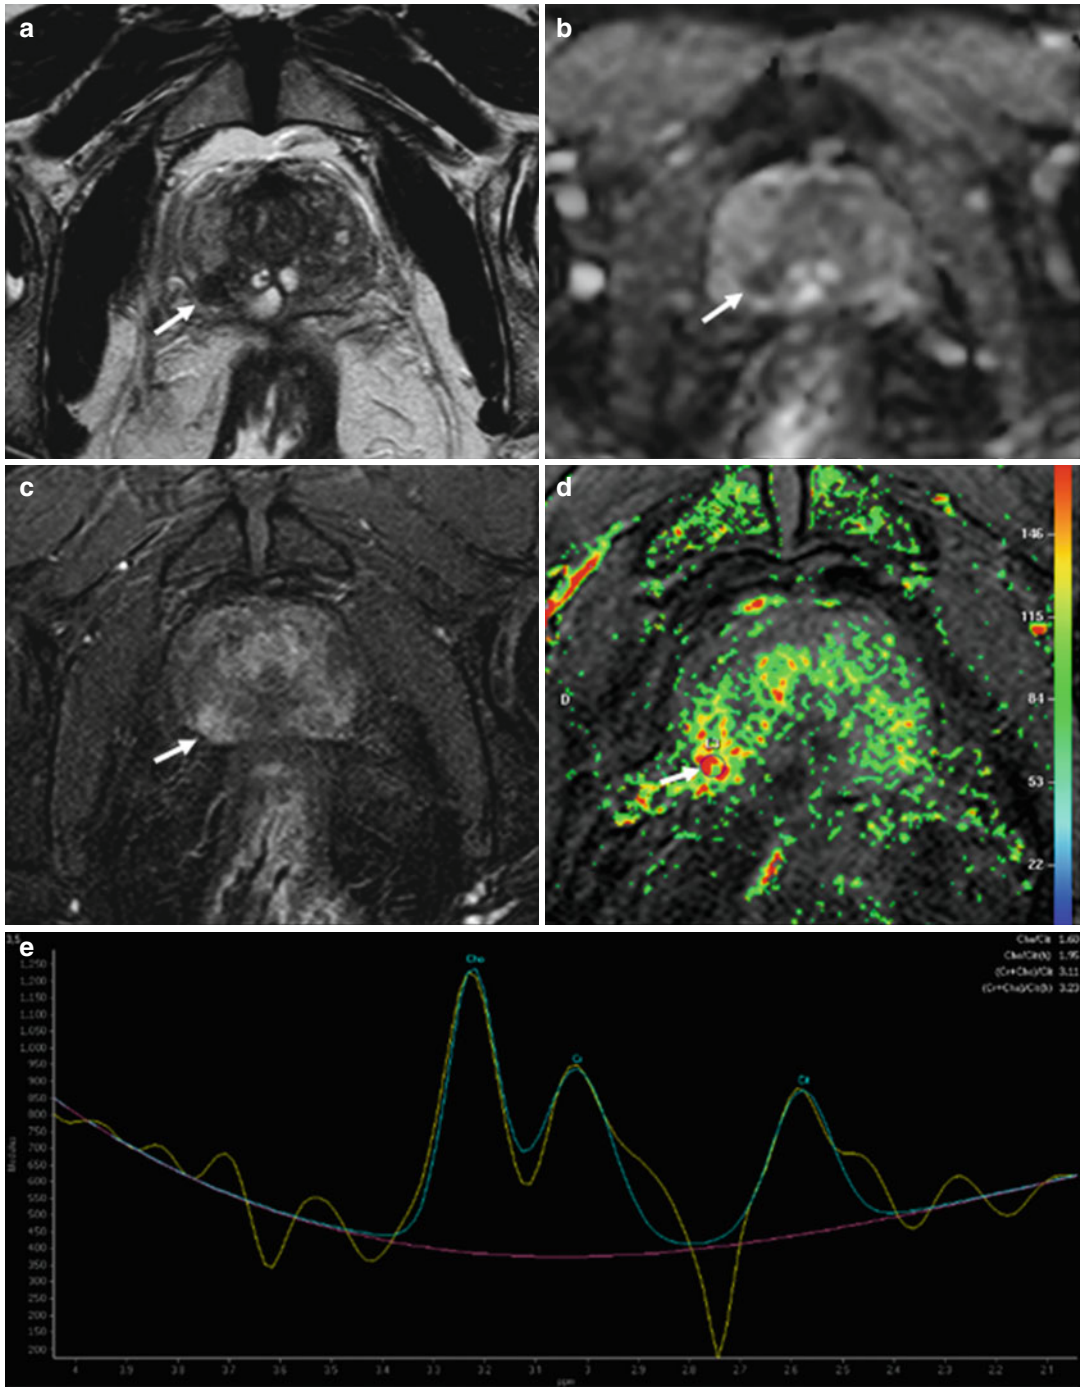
(a–e) 68 years old, Gleason 7 (3+4). On axial T2-weighted (TR: 4074; TE: 100) sequence (a), a small hypointense nodule (arrow) is appreciable in the right peripheral zone, posteriorly. On ADC sequence (b), the lesion (arrow) appears hypointense while on post-contrastographic phase (TR: 8.9; TE: 4.4) (c) hypervascularized. Although these features allow to diagnose a
